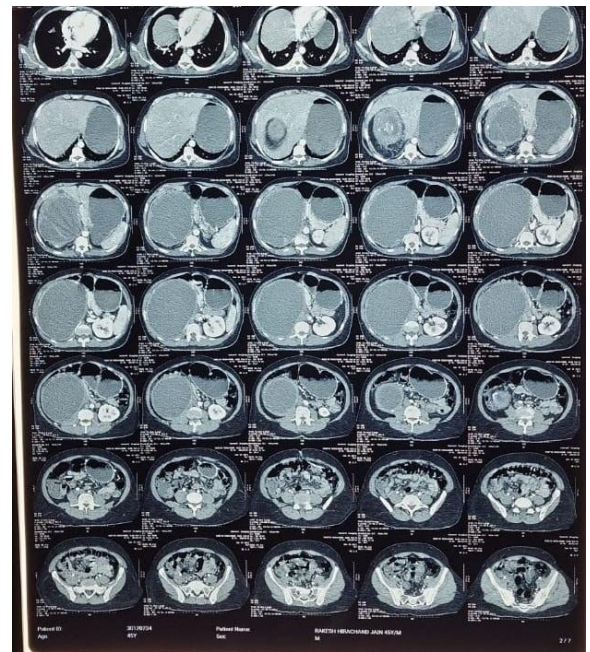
CT Image of Large Mass Arising from Renal Parenchyma
